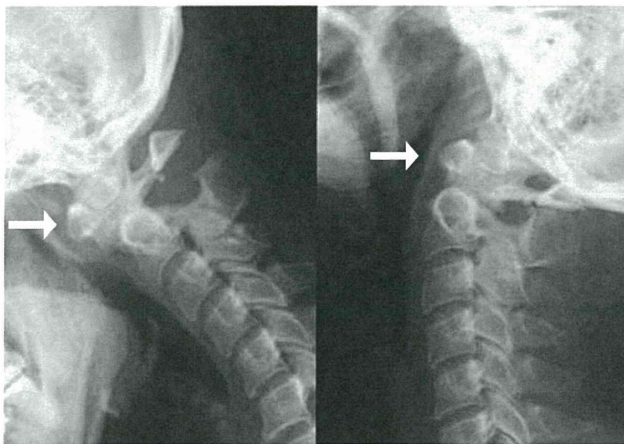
Flexion/extension lateral radiographs showing an os odontoideum (arrows) and atlantoaxial instability.
